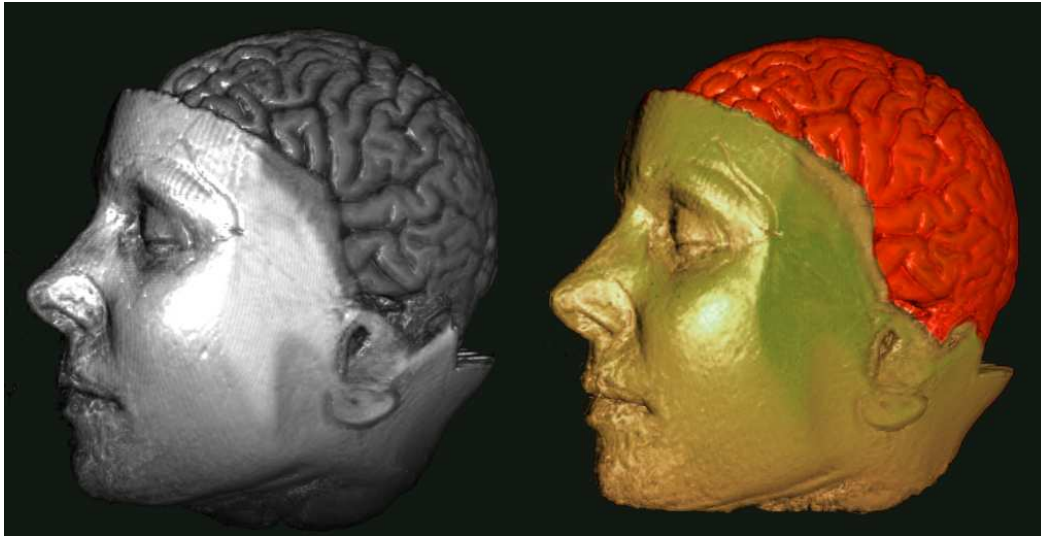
The MRI Head dataset [77] rendered with a simple greyscale transfer function (A) and with a transfer function that classifies soft tissue and brain tissue (B).
